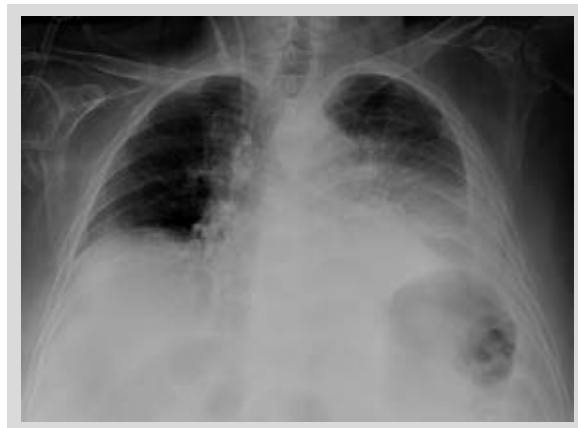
Chest X-ray posterior to octreotide infusion in the second patient.
